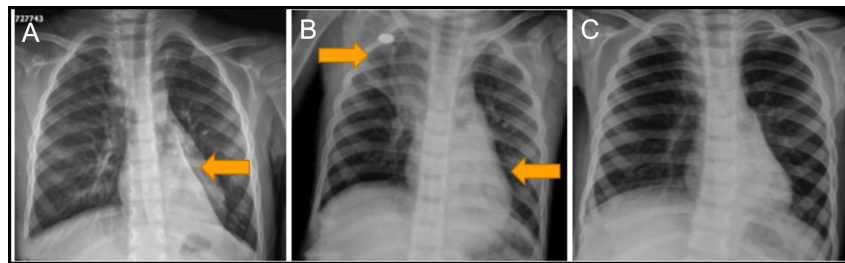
Left lower lobe atelectasis in the chest x-ray on admission (A). Right upper lobe and left lower lobe atelectasis on chest x-ray before the first bronchoscopy (B). Control chest x-ray a day after bronchoscopy and removal of the eosinophilic casts and a significant improvement of the atelectasis was observed (C).
